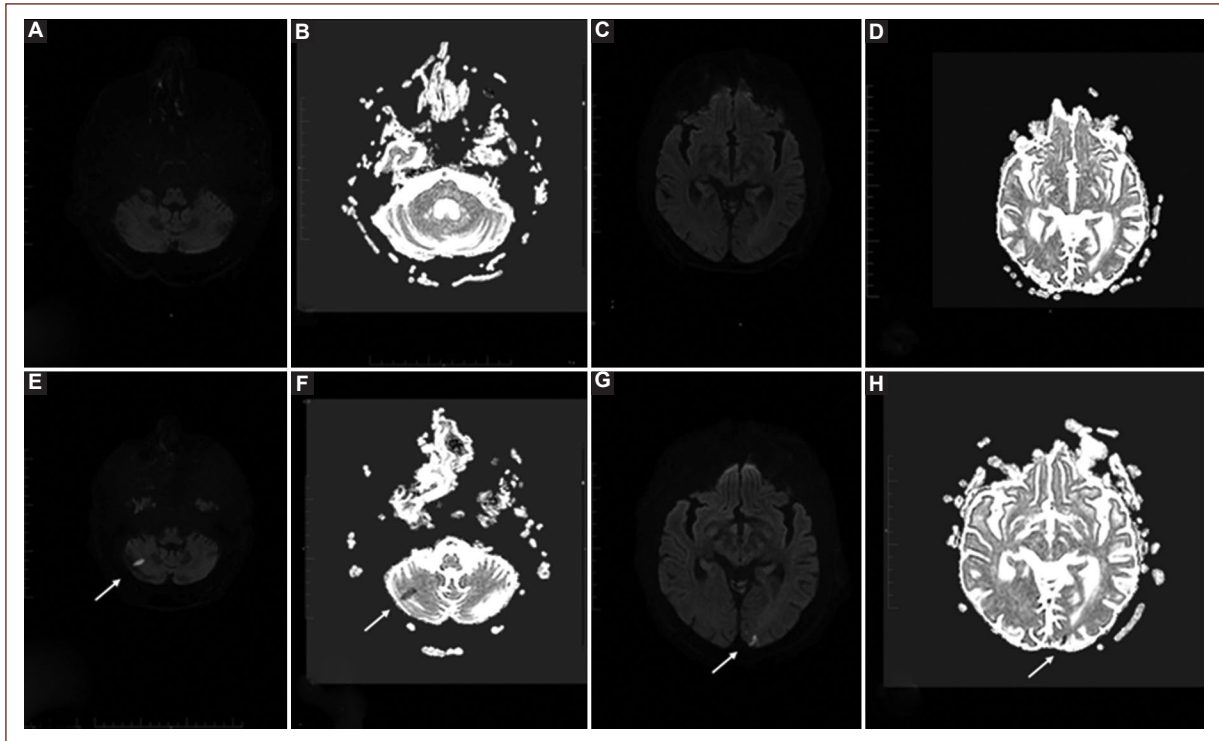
Magnetic resonance imaging of the brain with diffused weighted imaging (A and C), and apparent diffusion coefficient maps (B and D), performed 24 h before placement of the left carotid stent. No important findings are seen in the supratentorial and infratentorial. E-H: white arrows indicate multifocal areas with restriction of fluid diffusion located in the right cerebellar hemisphere and in the left occipital cortico-subcortical region, performed 24 h after left carotid stenting. No relevant clinical symptoms were observed in this patient.
